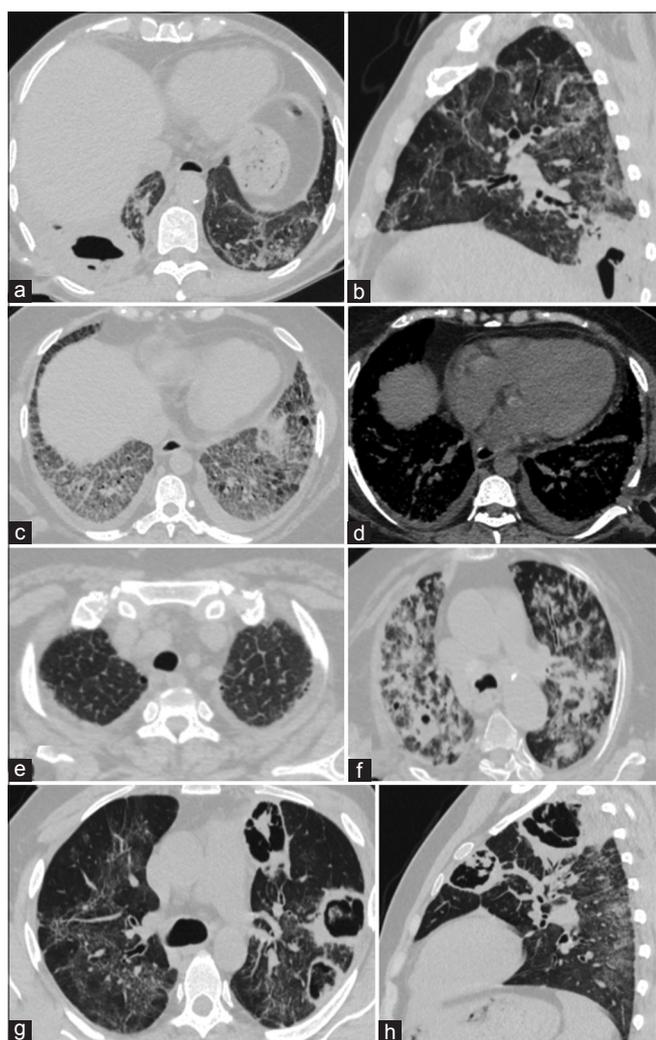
Axial and sagittal computed tomography (CT) images showing a patch of consolidation and the internal breakdown and cavity formation in the right lower lobe may be due to superimposed bacterial infection (a and b). Axial CT images of a patient showing ground glass opacities, interstitial edema septal lines, bilateral pleural effusion, and cardiomegaly indicating pulmonary edema (c-e). Axial CT image showing multiple nodules in bilateral lungs with cavitory nodule in the right lower lobe. Bronchial wall thickening is also noted (f). Multiple cavitory lesions with surrounding consolidation give a “Bird’s Nest sign” in the left lung highly suggestive of superimposed fungal infection (g and h)
